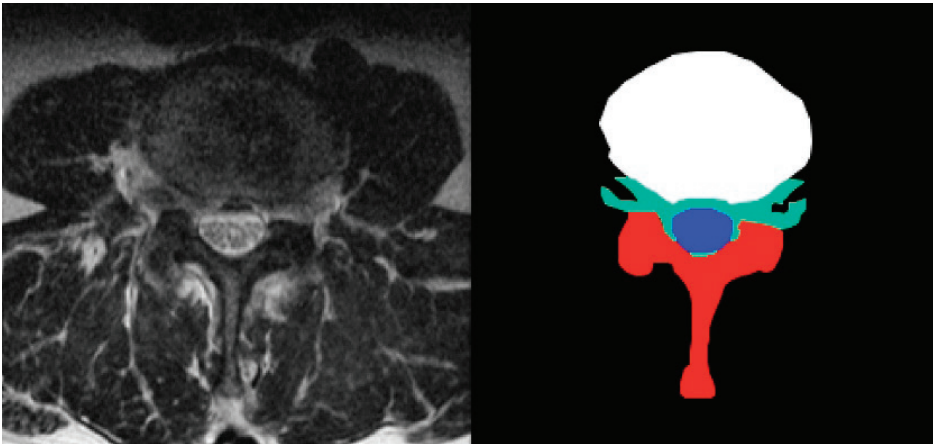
Example of segmentation of spinal structures in the lumbar spine from an axial T2-weighted MRI image
